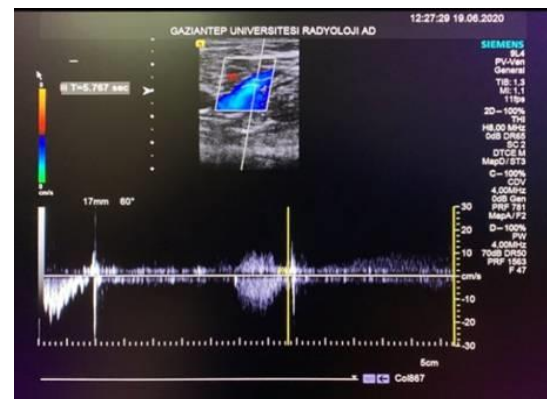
Colored Doppler ultrasound evaluation of venous reflux
